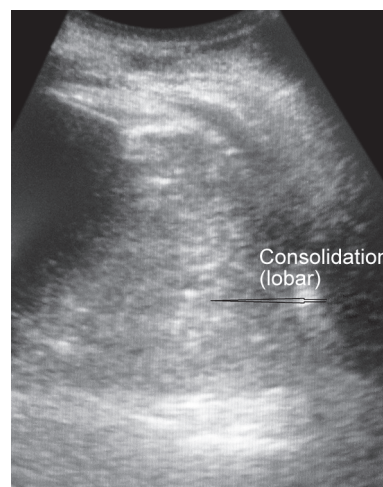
Lung ultrasound demonstrated lobar consolidation
